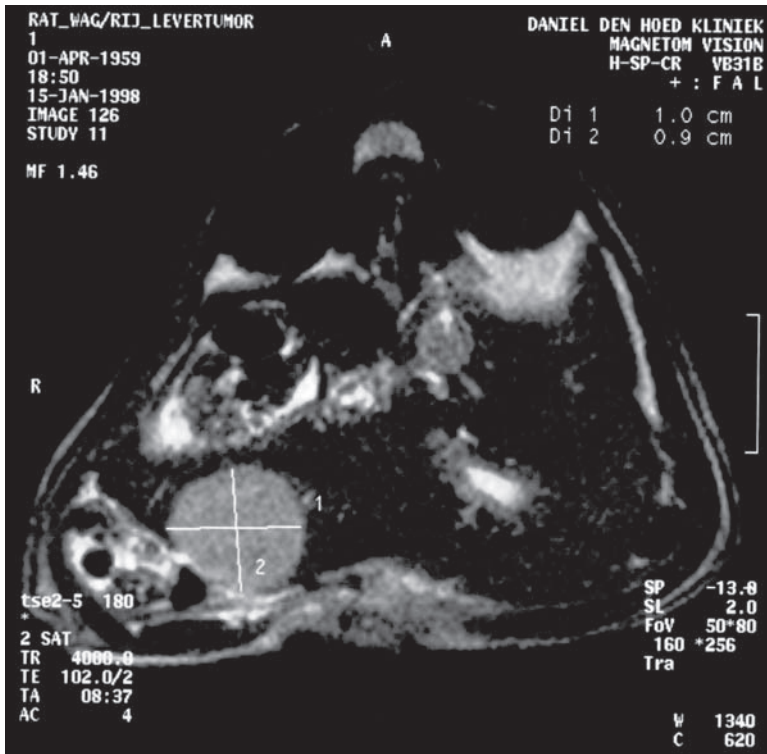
(*continued*) Tumor growth, which was measured repeatedly, was not different from endpoint measurement. This was confirmed by a noninvasive technique, MRI (B). Tumor volume of a ROS-1 osteosarcoma was measured 14 d after implantation showing diameters of 1.0 and 0.9 cm and a length of 1.5 cm (not shown), that correspond with the tumor size measured with calipers.
